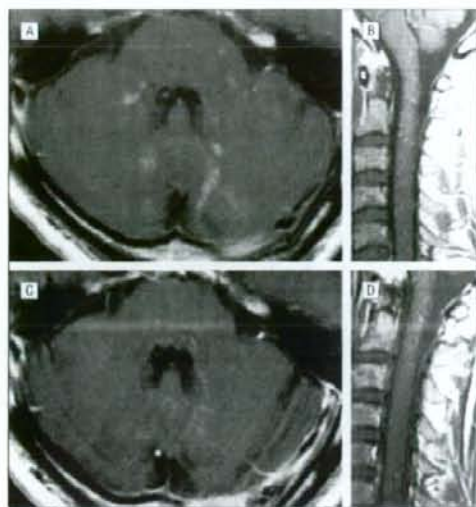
T1-weighted images with gadolinium enhancement of the cerebellum, pons, and cervical cord after treatment. A and B, The pons (A) and cerebellum (B) 1 month after treatment. C and D, The pons (C) and cerebellum (D) 8 months after treatment.
